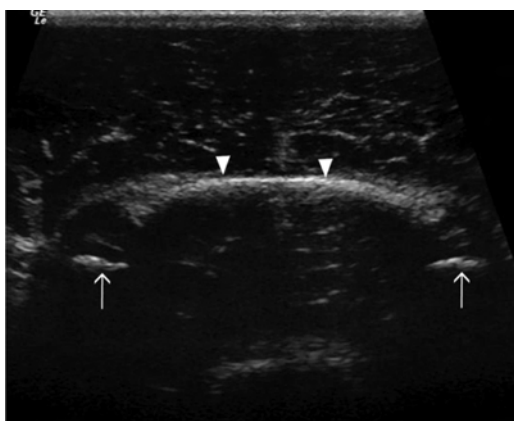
Transverse plane ultrasound image of the basihyoid bone (arrowheads) and the ceratohyoid bones (arrows) of a normal larynx, obtained with the transducer positioned ventrally. Left is to the left of the image and right is to the right of the image.
